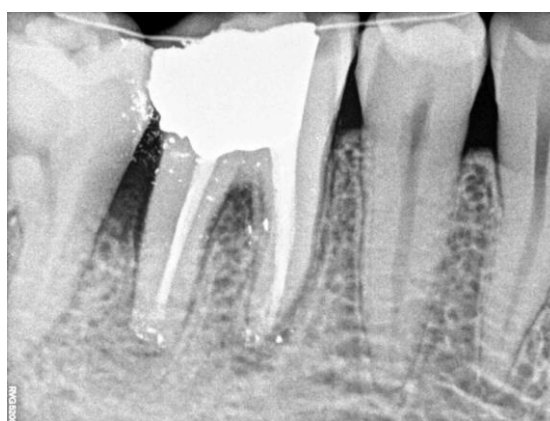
Immediate postoperative Xray after splint placement.
